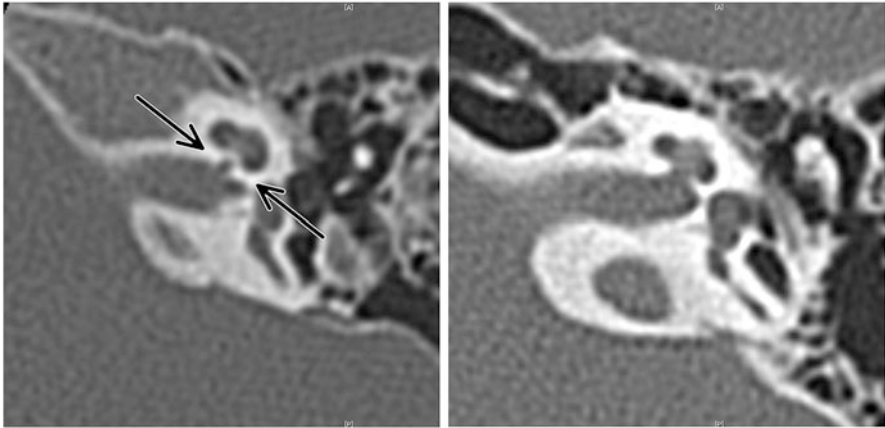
CT images showing narrow (*left*) and normal (*right*) bony cochlear nerve canals. Normally, the bony cochlear nerve canal does not resemble a canal. In patients with poorly developed cochlear nerves, however, this structure becomes constricted and resembles a narrow canal (*arrow*)
